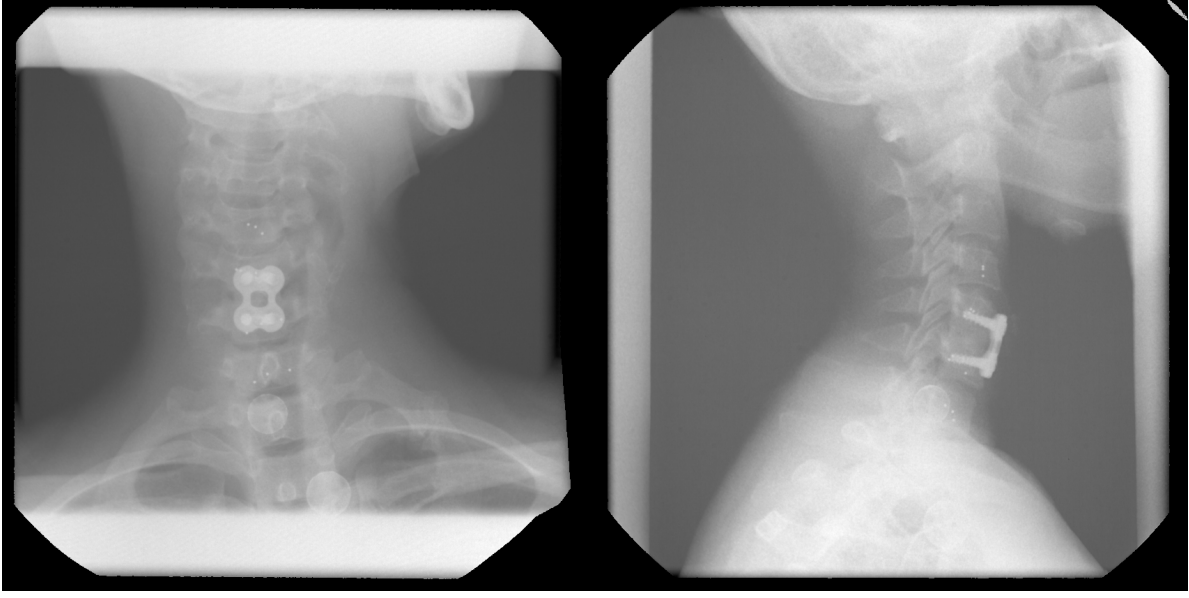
Two frames of the high resolution (1024x1024) radiograph sequences which are captured during motion from the dynamic stereo X-ray system.
